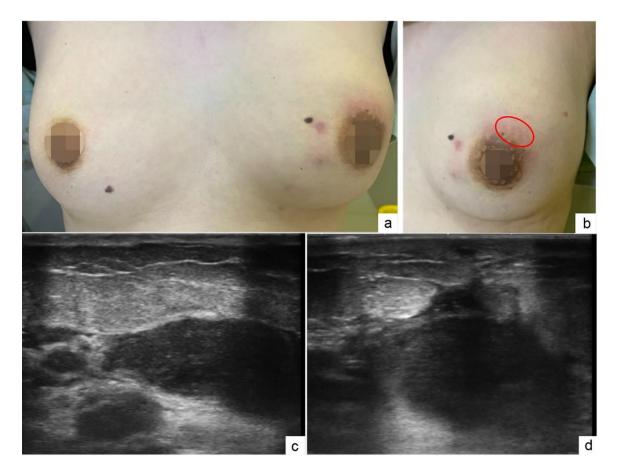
Congestive swelling stage. a, b Granulomatous lobular mastitis in a 29-year-old woman with a painful mass of 3 months' duration in the upper outer quadrant of the left breast, with hyperaemia and swelling skin, without nipple retraction. c, d Larger hypoechoic mass $(6.8 \text{ cm} \times 2.8 \text{ cm})$ was detected by ultrasound
